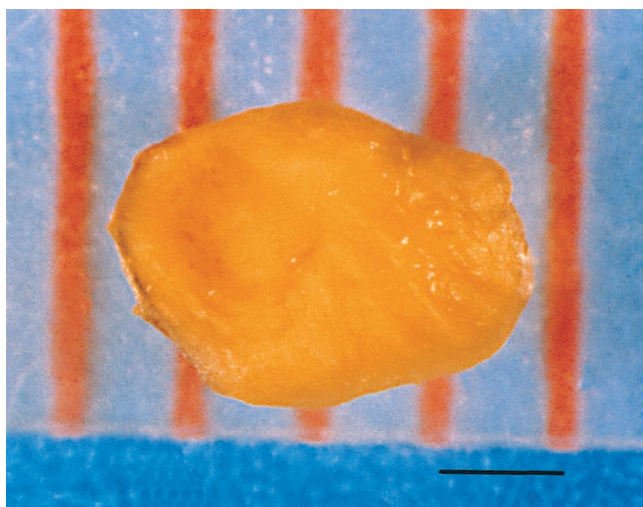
Sulfur granule recovered from refractory periapical endodontic lesion. The granule was soft, yellowish in color, and 3 to 4 mm in diameter. Three additional sulfur granules were recovered from the same lesion. Bar = 10 mm.
